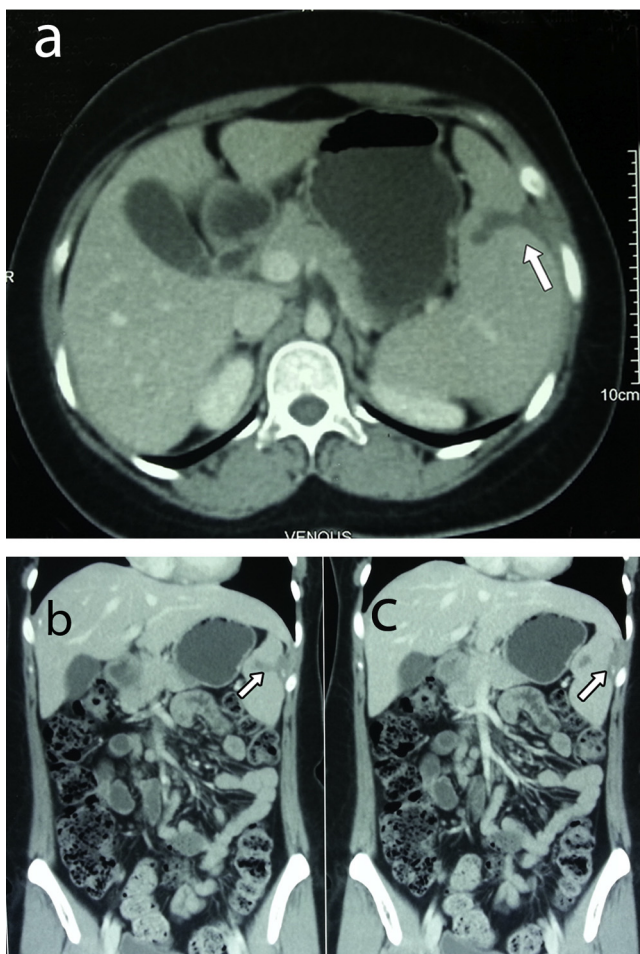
a, b & c – Axial and Coronal Sections of Computed Tomography of abdomen, with arrow showing multiple splenic abscess.
